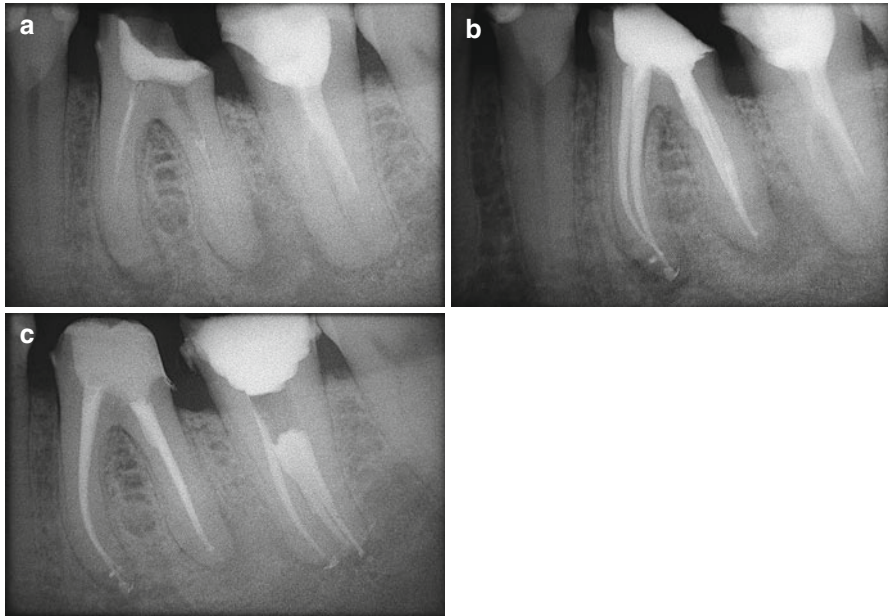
(a) Preoperative radiograph. Left mandibular first molar with insufficient endodontic treatment and apical, mesial, and distal radiolucent areas, indicative of asymptomatic apical periodontitis. (b) Postoperative radiograph. Retreatment. (c) Follow-up at 6 months
